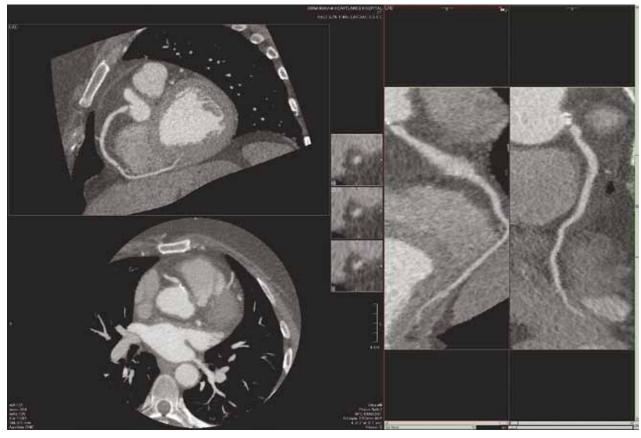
Cardiac CT image demonstrating an ostial RCA stenosis
